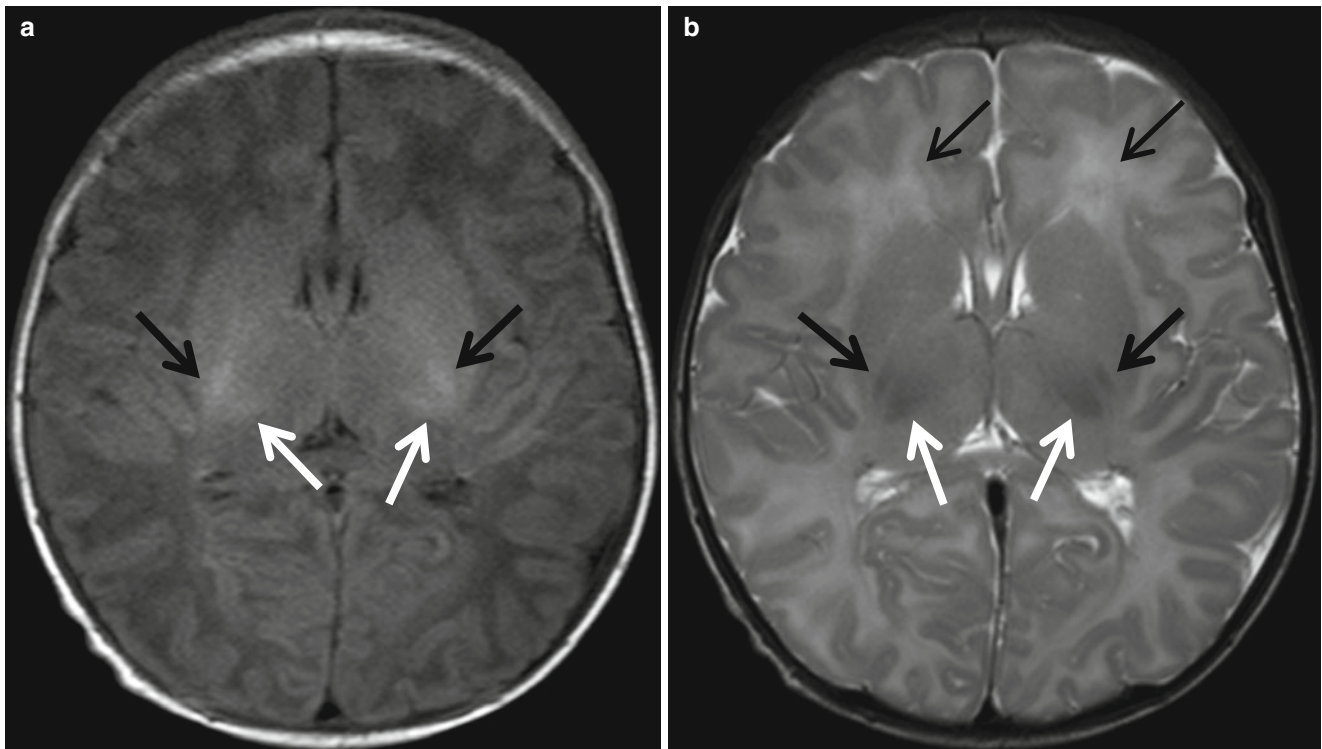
MR images in a normal 4-day-old full-term neonate. (a, b) Axial T1-weighted image shows normally increased signal intensity of posterior limb of internal capsule (*arrows*) and ventrolateral nucleus of the thalami relative to basal ganglia and thalamus (*white arrows*). (b) The
